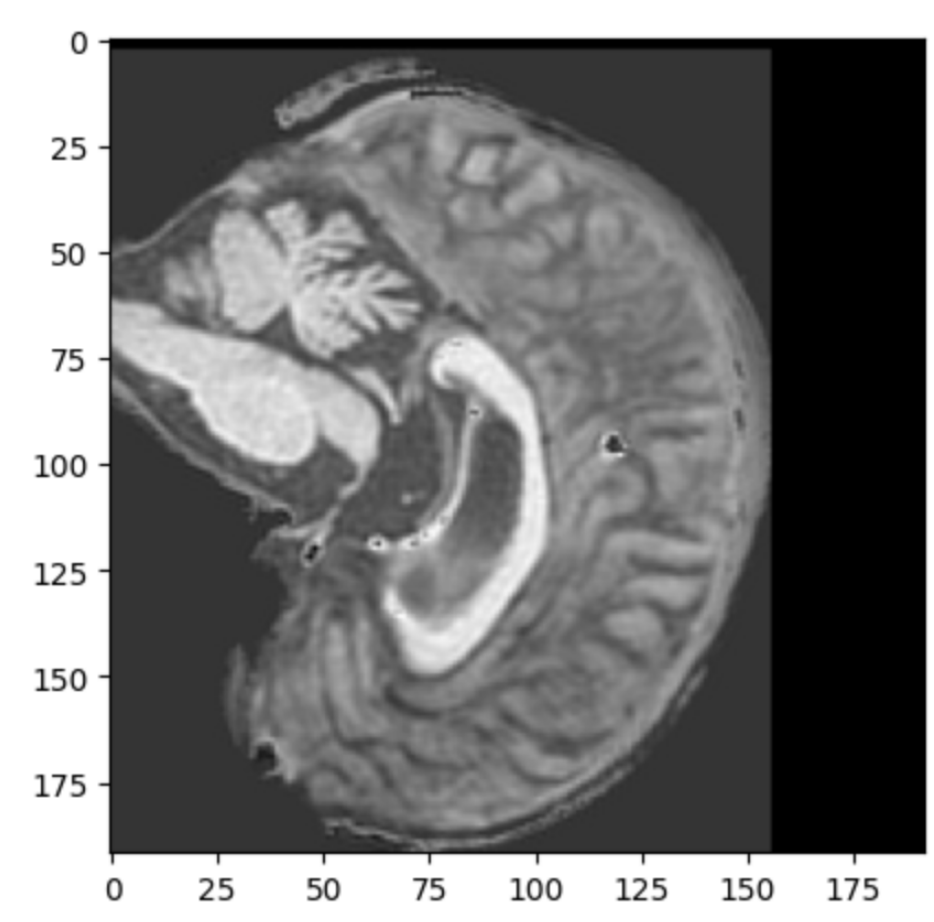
Square Preprocessed MRI of height and width as 192 units
